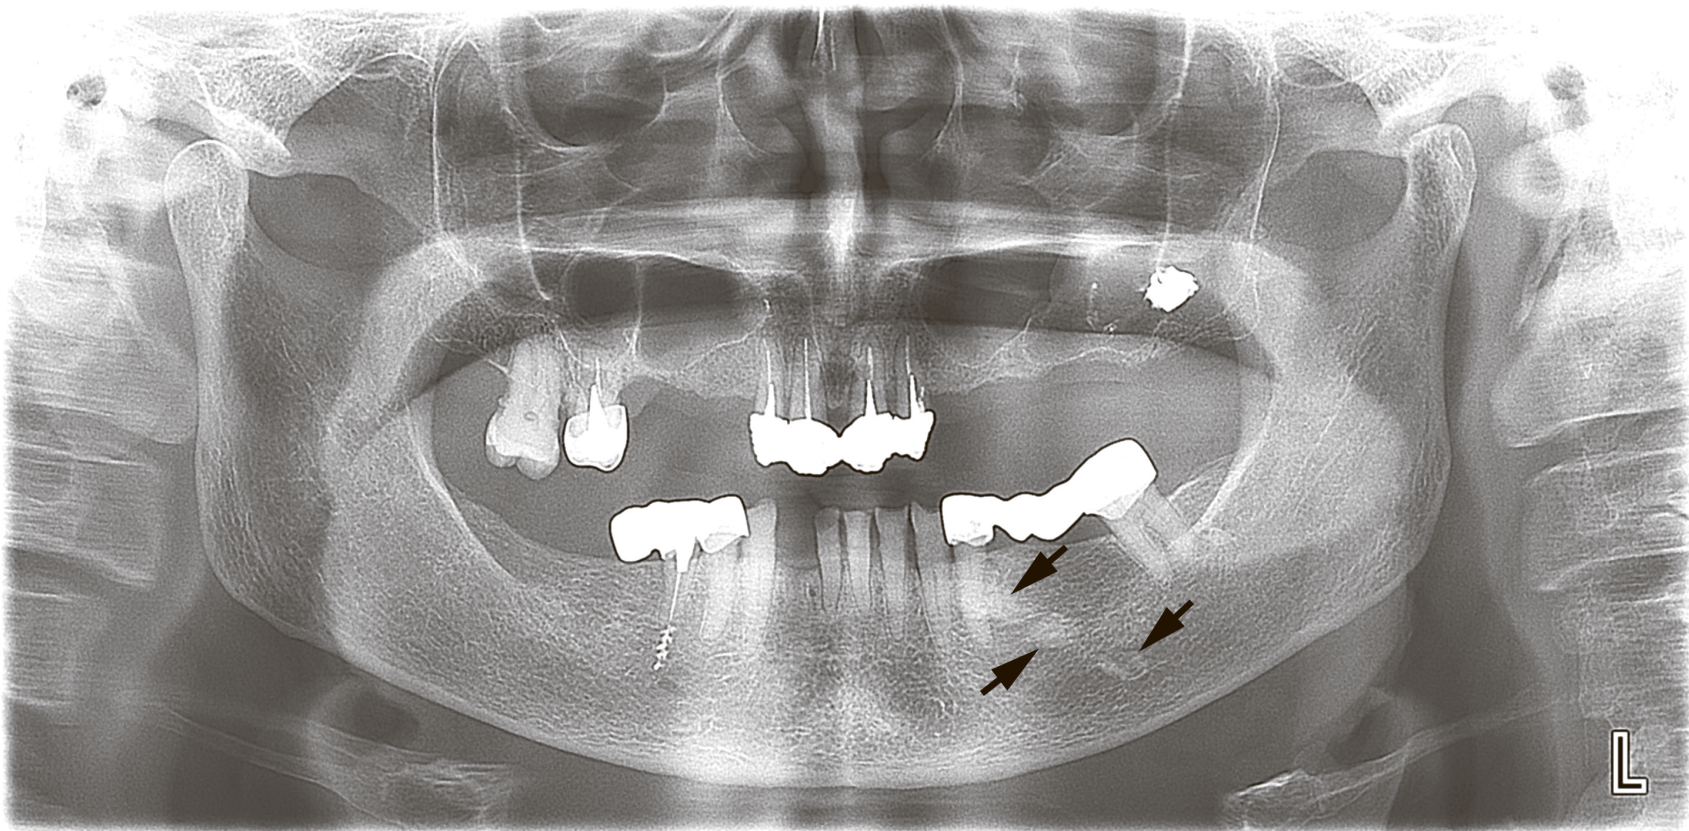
Case 7: An orthopantomogram of 74-year-old lady shows three radiopaque salivary stones (*arrows*) in the projection of left Wharton's duct.
